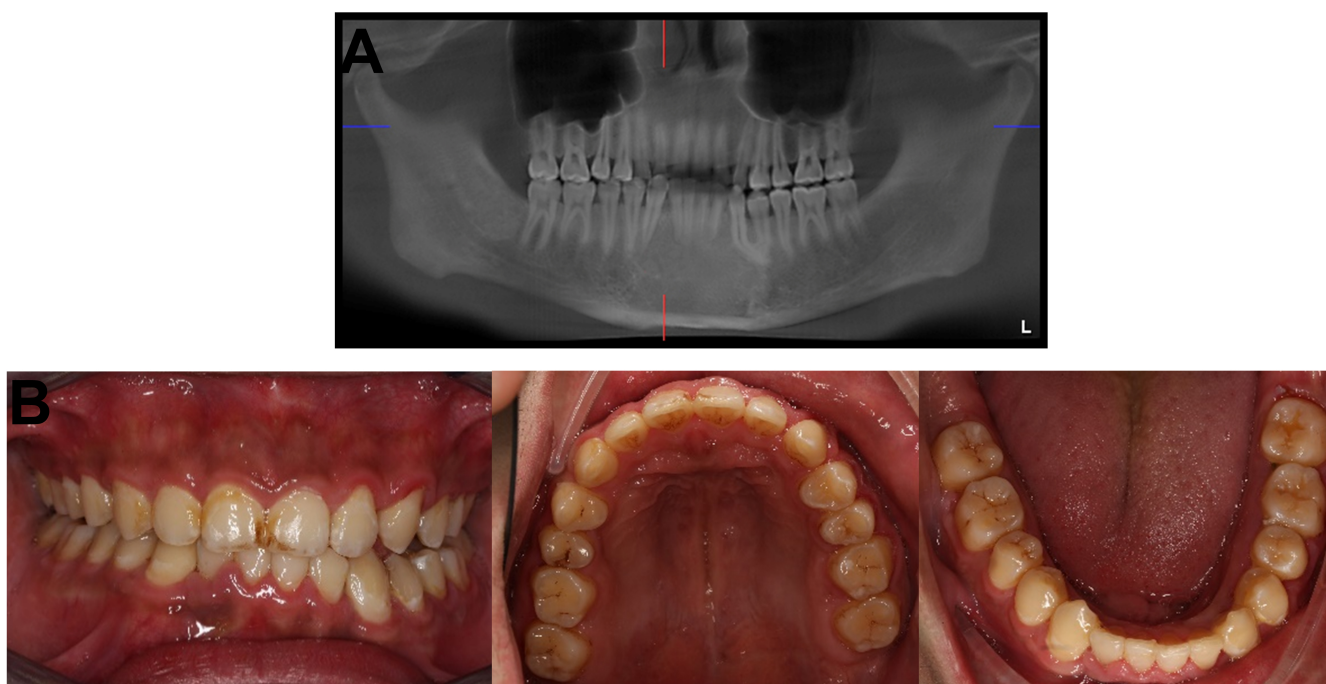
Intraoral photograph and panoramic radiographs after the treatment. (A) After the orthodontic treatment, the impacted teeth were aligned. (B) The photo after the comprehensive treatment.
